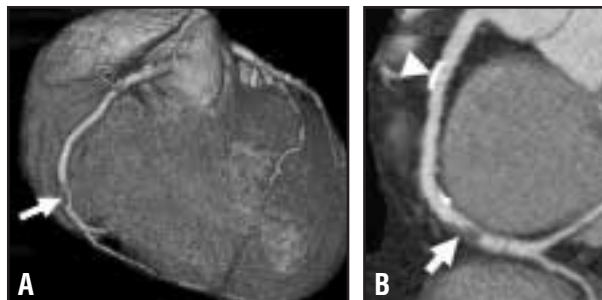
A: 64-year-old with an RCA stenosis depicted on coronary CTA (arrow). B: Reformatted image depicts a large soft plaque (arrow) and a smaller calcified plaque (arrowhead).
